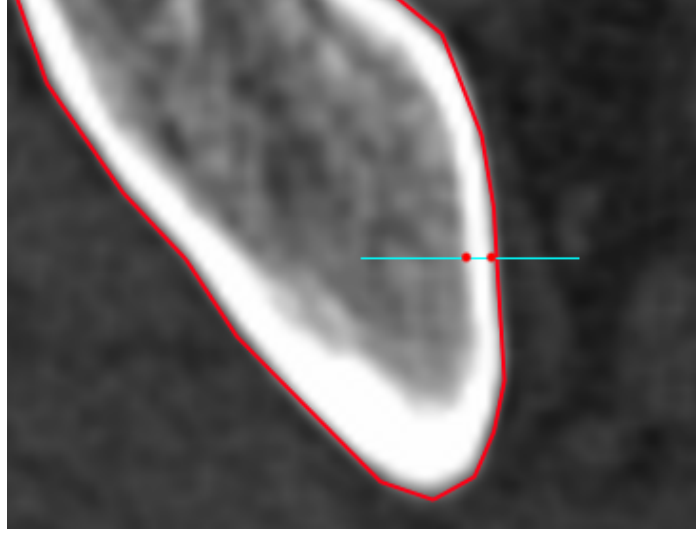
An example of measuring the cortical thickness along the cyan line through the cortical and trabecular bone. This image is a screenshot taken from Stradview [133]. The underlying CT image is from the Addenbrooke's Hospital CT Data Collection.
